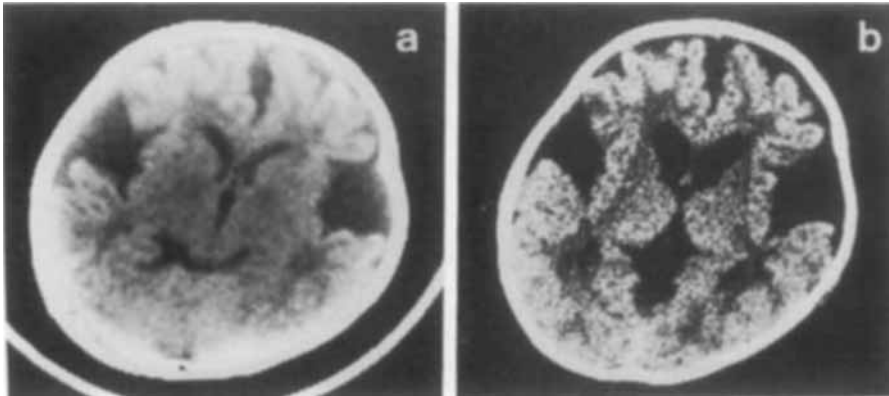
Brain CT of Case 2 at (a) 7 months and (b) 16 months of age.
